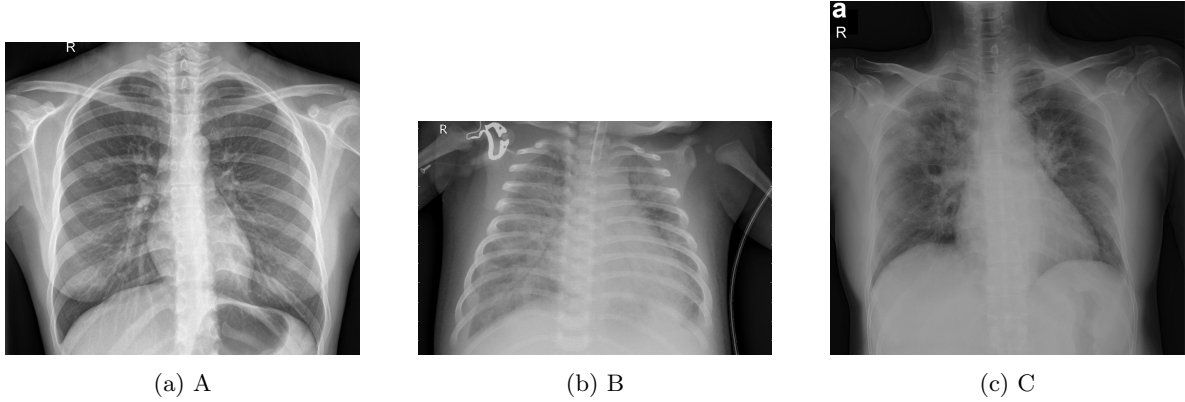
A shows a chest XRay of a healthy patient. Both lungs are clearly visible as darker areas. B shows a chest XRay of a patient suffering from non-viral pneumonia and C the XRay Covid19 induced pneumonia. In both images the fluid infiltrated alveoli let the lung appear white to grayish where as the air filled bronchi appear as dark lines.
